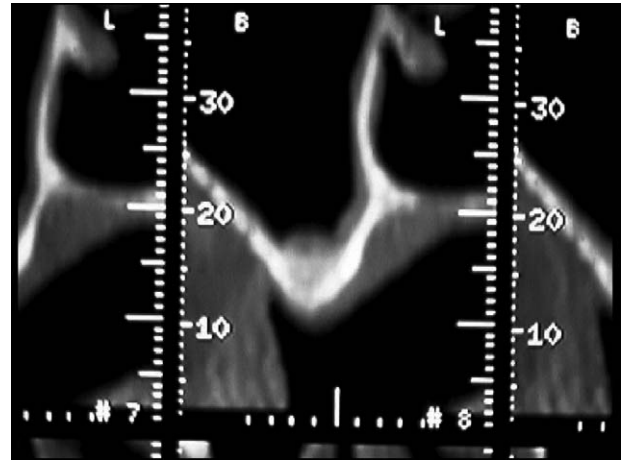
Preoperative CT scan showing a limited amount of available bone.
